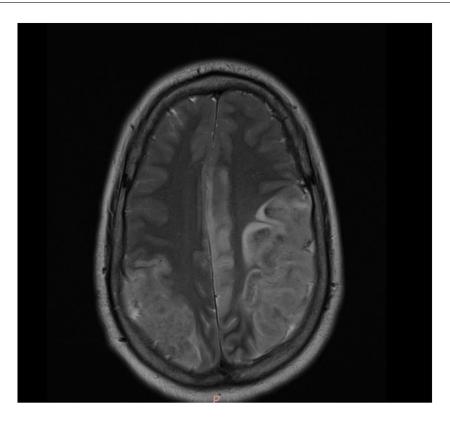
MRI image in T2 sequence showing bilateral parieto-occipital hypersignal related to bilateral posterior lobe ischemia.
